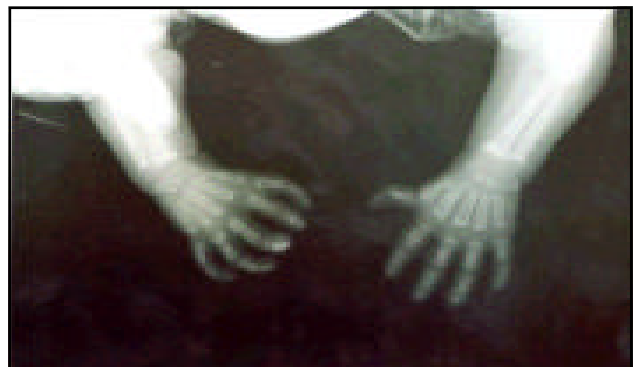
Hand x-ray roentgenography .
